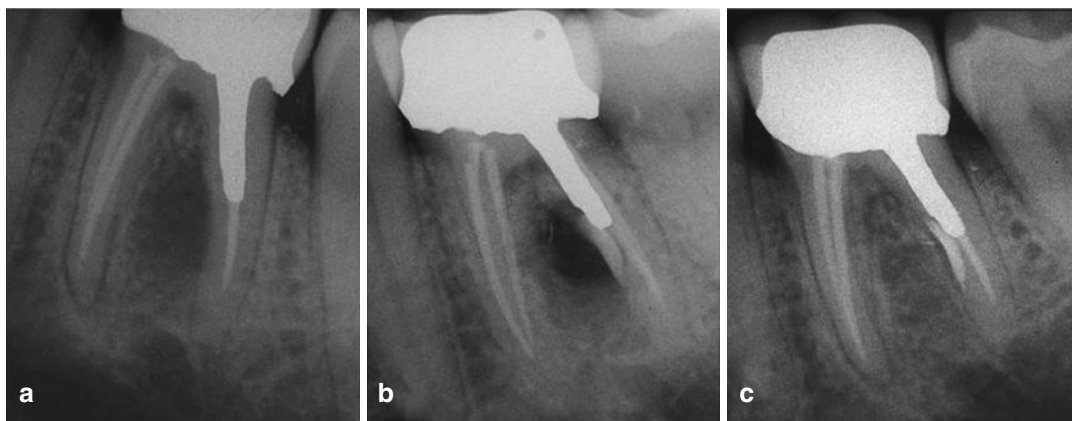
Preoperative x-ray of first mandibular molar with a root perforation following a post preparation. Furcal radiolucency is noted at the distal root (a).
